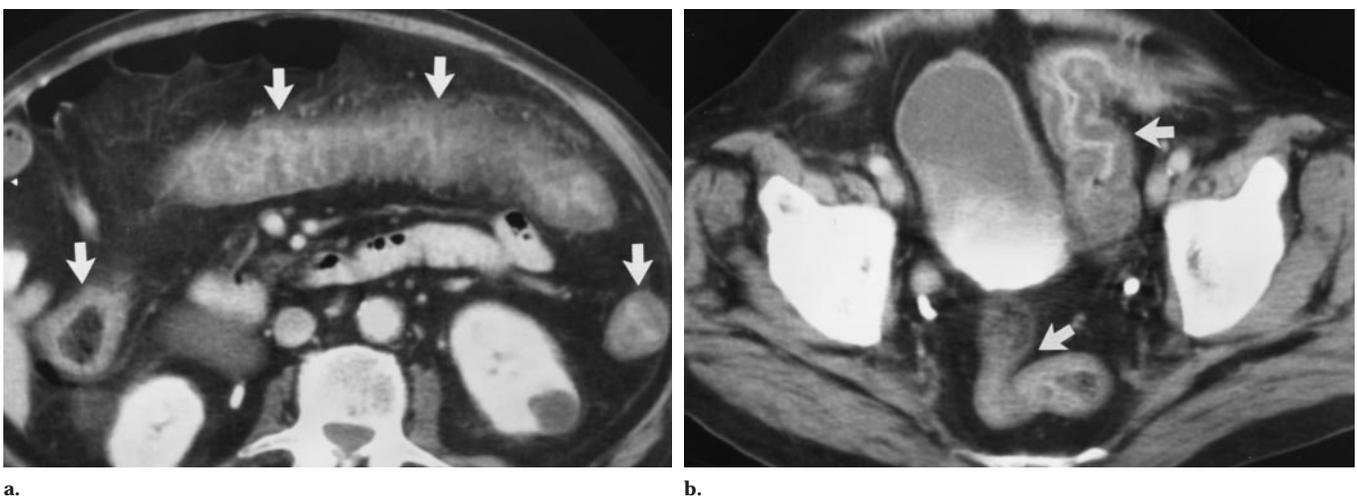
Ischemia involving the entire colon in a 77-year-old man with relapsing chondritis, arteriosclerotic heart disease, and myocardial infarction, who had previously undergone coronary artery bypass surgery. Abdominal pain and rectal bleeding were present. (a) Contrast-enhanced CT scan shows heterogeneous enhancement and wall thickening of the transverse colon, as well as the right and left colon (arrows), with loss of haustral markings. (b) CT scan shows sigmoid colon and rectum (arrows) with alternate layers of high and low attenuation consistent with edema. Findings mimic an acute inflammatory colitis. Diagnosis was confirmed at colonoscopy. A benign cyst is present in the left kidney.
